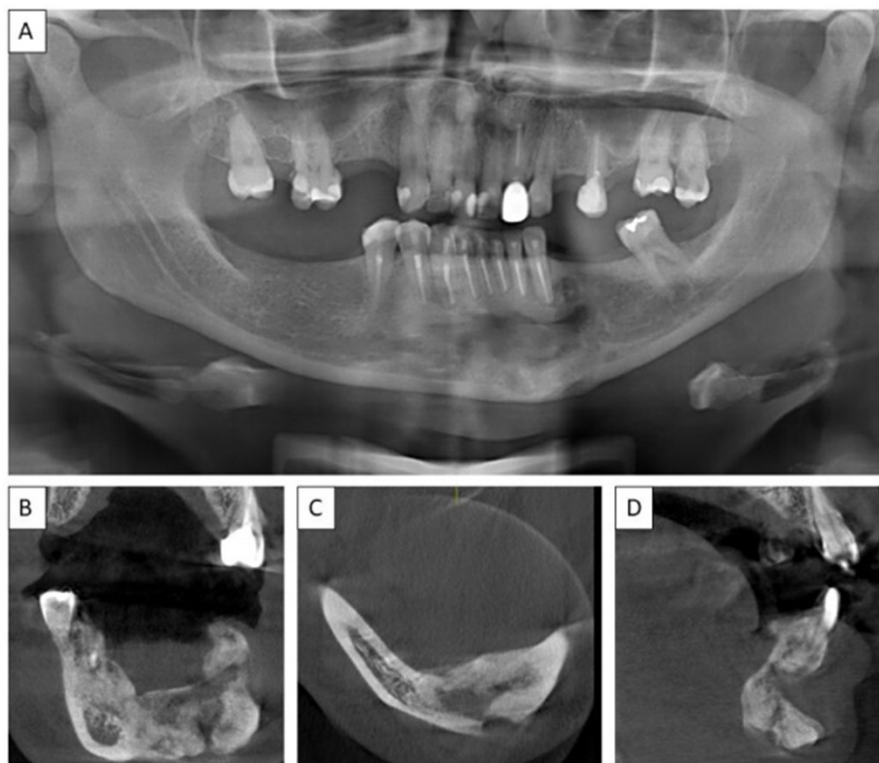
A) Ten-months postoperative panoramic radiograph, with bone neof ormation; ten-months postoperative cone beam CT; B) Coronal section; C) Axial section; D) Sagittal section, bone neof ormation.
